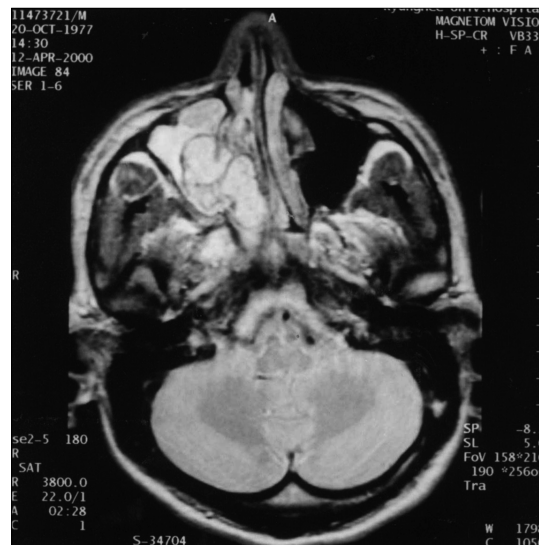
T2-weighted MRI scan shows inhomogeneous intermediate to high signal intensity of the mass in the right maxillary sinus and nasal cavity.
